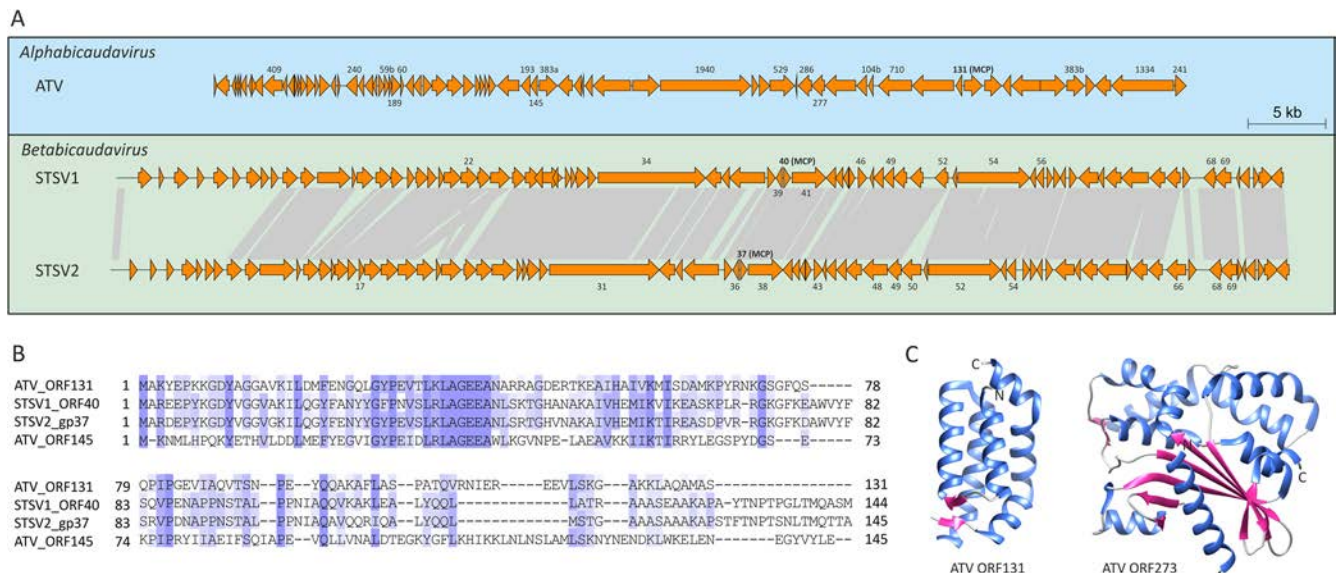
Evolutionary relationship between spindle-shaped viruses with tails. (A) Genome maps of *Acidianus* two-tailed virus (ATV) and *Sulfobolus tengchongensis* spindle-shaped viruses 1 and 2 (STSV1 and -2). Homologous regions shared between STSV1 and STSV2 are connected by gray shading. Names of ATV genes that have homologs in STSV1 and/or STSV2 are indicated; the names of corresponding STSV1 and STSV2 genes are also shown. The new genus “*Betabicaudavirus*” within the family *Bicaudaviridae* is proposed for classification of STSV1 and STSV2. (B) Multiple alignment of major capsid protein sequences of ATV, STSV1, and STSV2. Note that products of ATV ORF145 and ORF131 are paralogs. GenBank identification (GI) numbers: ATV ORF131, 75750454; ATV ORF145, 75750440; STSV1 ORF40, 51980166; STSV2 gp37, 448260184. (C) Available X-ray structures of two ATV structural proteins, ORF131 (PDB ID no. 3FAJ) and ORF273 (PDB ID no. 4ATS), both displaying unique folds. Whereas a homologue of ORF131 is encoded by both STSV1 and STSV2 (A and B), ORF273 is unique to ATV.
